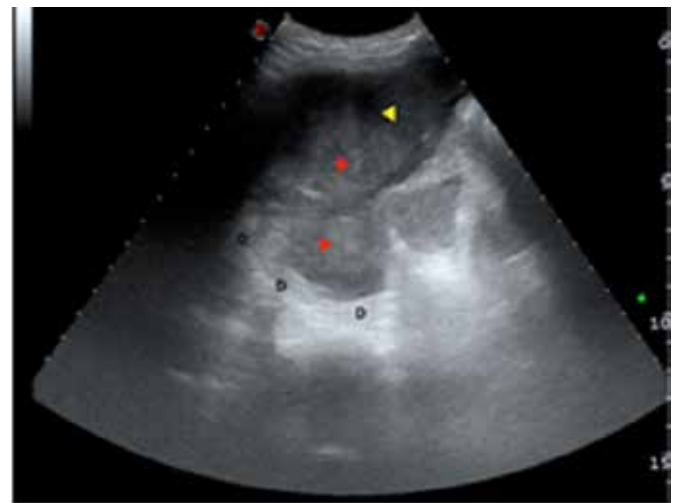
FAST of a splenic trauma, later confirmed by computed tomography, and the patient treated with laparotomy<sup>10</sup>.
